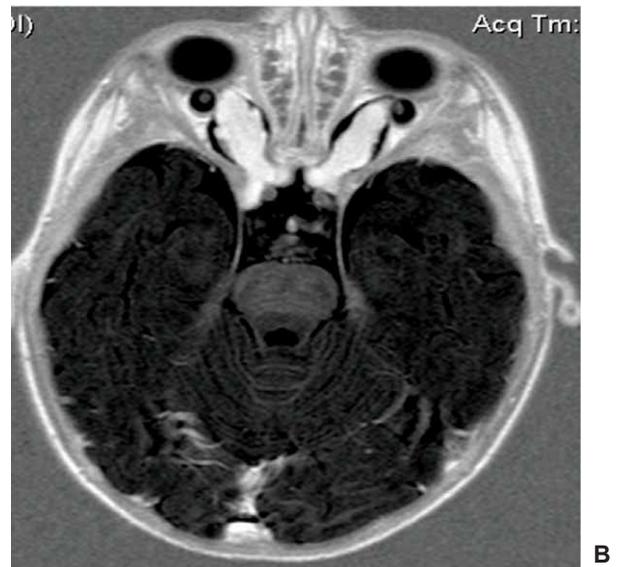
MRI cranio-cerebral: right optic nerve fusiform enlargement with isosignal T1 (A) and hipersignal T2 (B) (personal case)
